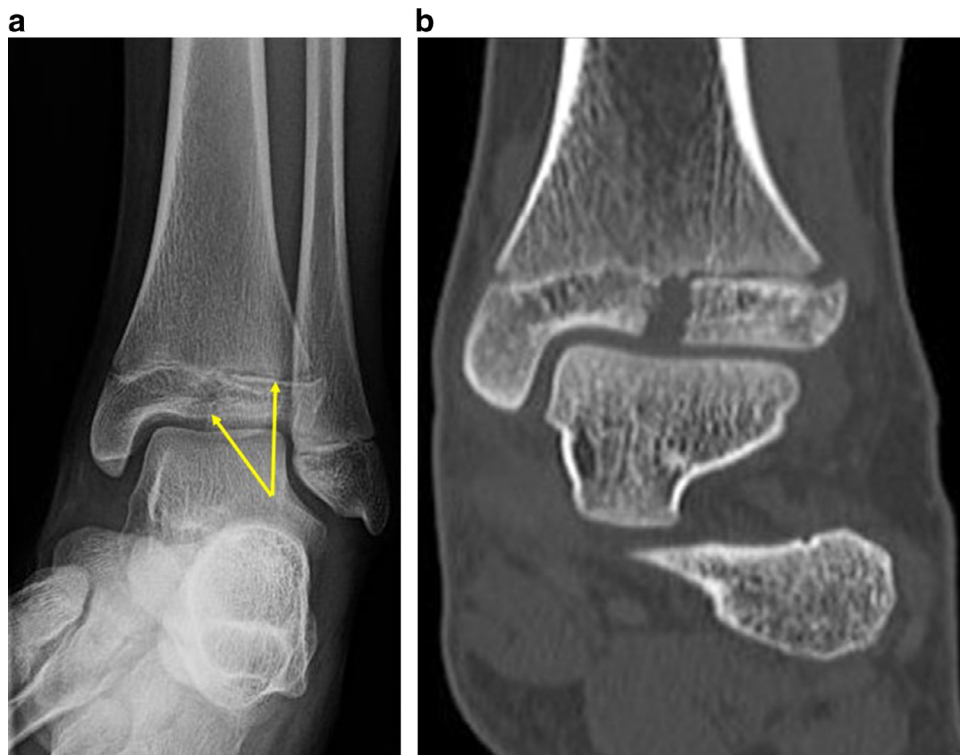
Thirteen-year-old boy injured while playing football. Oblique radiograph (a) demonstrates the Salter-Harris III fracture components of the juvenile Tillaux fracture (arrows) and the coronal reformatted CT image (b) for operative assessment.
